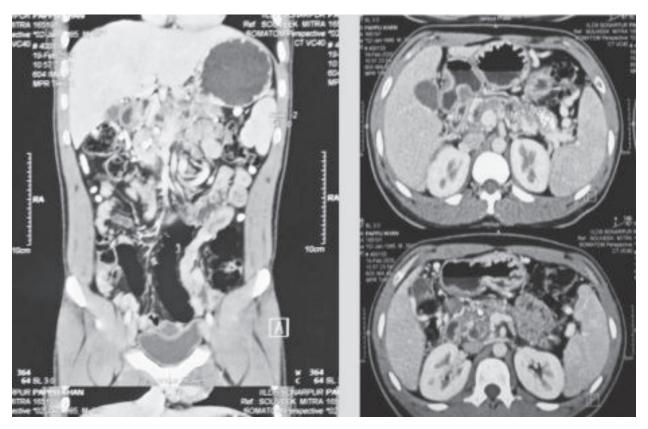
CT Scan images of Chronic calculus pancreatitis of patient who underwent LPG (Image courtesy: Dr. Rajib Dey Sarker, Bangladesh 2019, rajibdeysarker@gmail.com)
